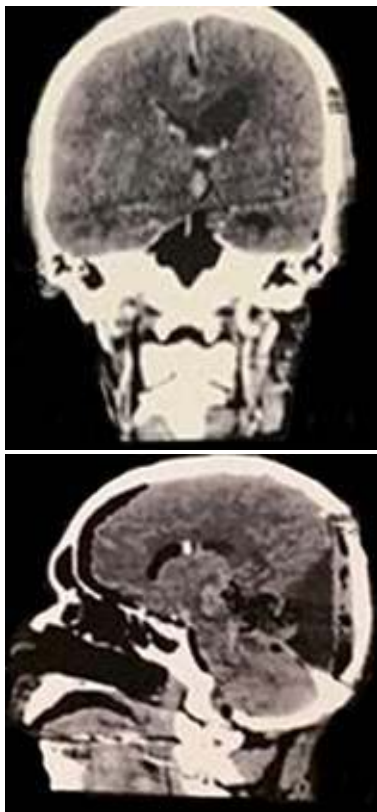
The post-surgery computed tomography revealing surgical complications.
